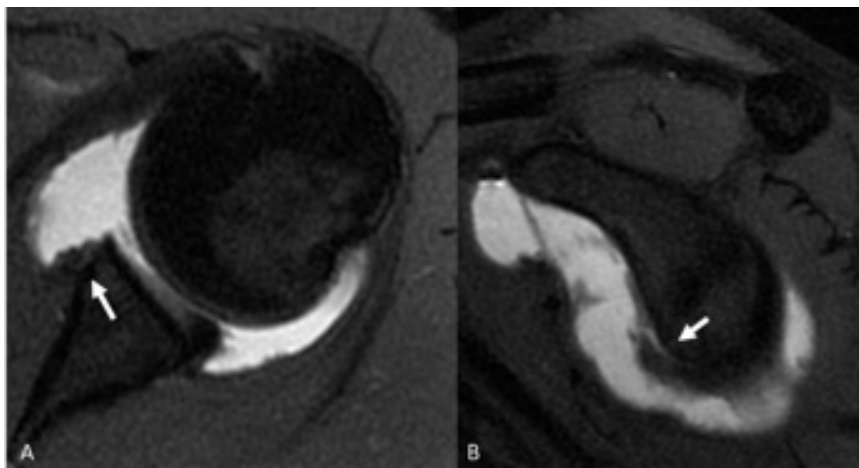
A 24-year-old man with ALPSA lesion. A) Axial T1-weighted fat-suppressed MRA image shows a detachment of the anteroinferior labrum which remains attached to the periosteum and is shifted medially (arrow); B) Sagittal T1-weighted fat-suppressed MRA image demonstrates the presence of contrast material between the anteroinferior glenoid and the labrum (arrow).
